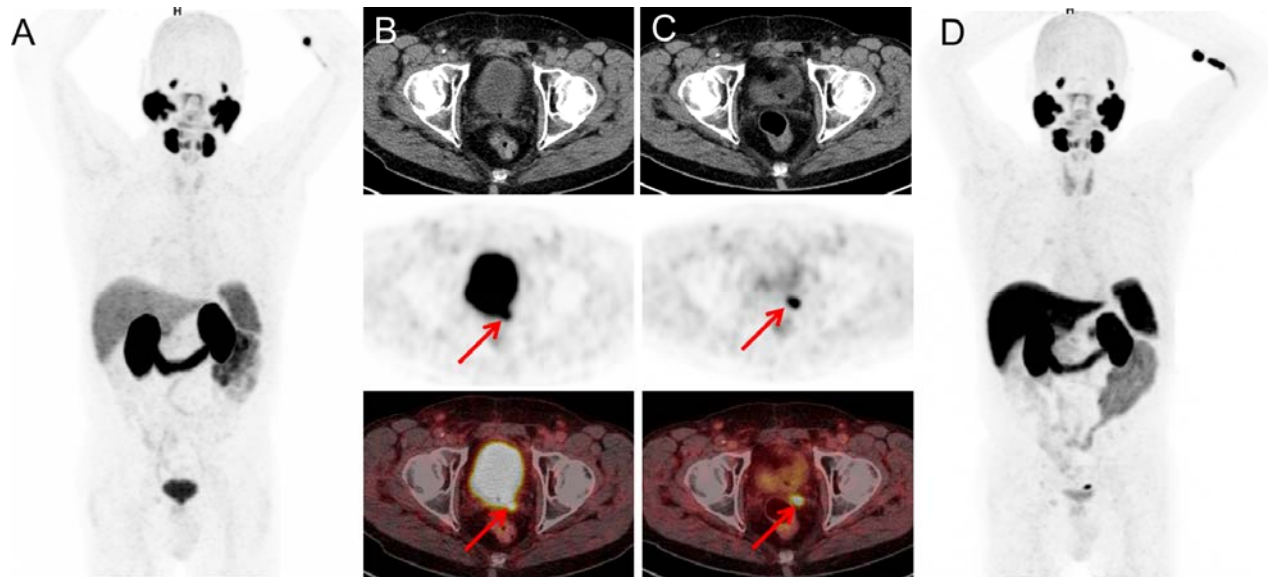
Set of images of a 76 year old patient with status post radical prostatectomy (2006, Gleason Score 7b, pT3a, pN0) and slowly rising PSA-value of 0.78 ng/mL (10/2017). The patient underwent primarily a [^{68}Ga]PSMA-11 PET/CT (A,B) resulting in the suspicion of local recurrence. No definite diagnosis could be made based on adjacent high activity retention in the urinary bladder. Subsequent [^{18}F]PSMA-1007 PET/CT (C, D) three month later clearly depicts PSMA-ligand uptake in the left seminal vesicle with high contrast and very low retention in the bladder.
